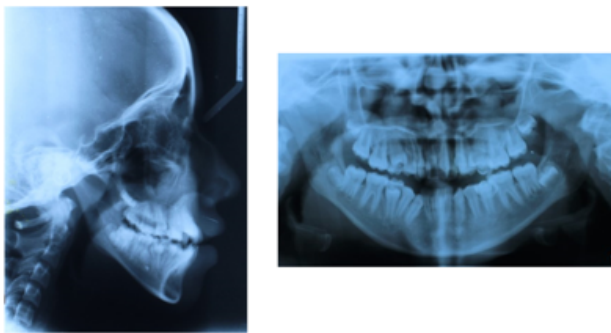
Pretreatment radiographs (Lateral cephalogram & OPG)
